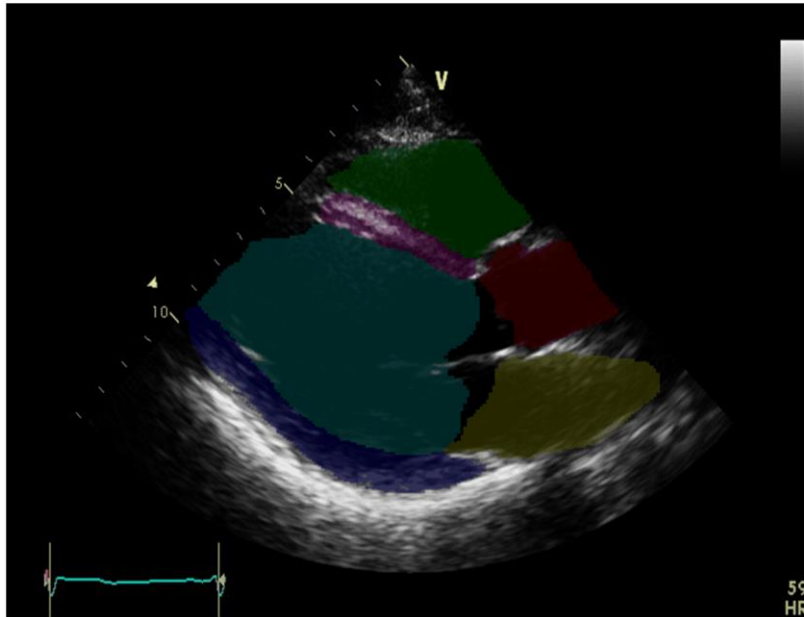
a) Segmentation in normal echocardiogram, b) Area of each chamber represented by the number of pixels shows change in area during the cardiac cycle.
